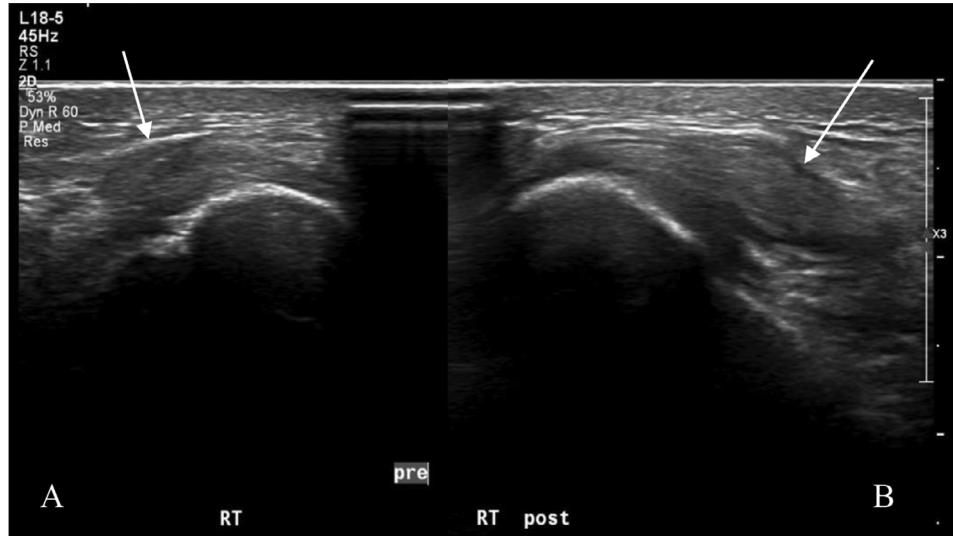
Dynamic ultrasound images before (A) and after (B) extreme flexion showed snapping of the tendon over the fibular head from anterior to posterior positions over the posterior cortical bump
